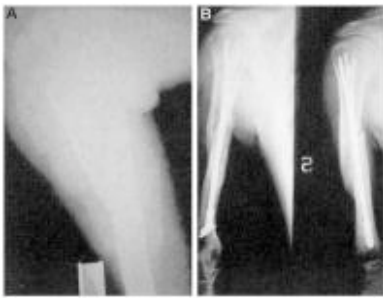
Preoperative (A) and follow-up radiographs (B; at 16 weeks) of a patient treated with IEN (L.M.; Table 2).
